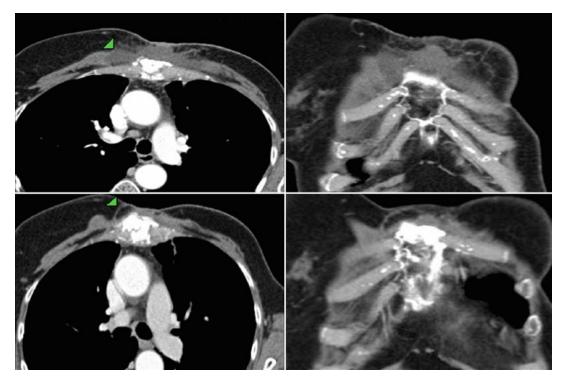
Chest wall cryotherapy – follow-up: The hypovascular zone at 1 month post-BC (top row arrow-heads) corresponding to the approximate visible ice extent 1 cm beyond lateral tumor margins. Enhanced axial and coronal CT images 18 months post-BC (*Bottom line*) show
